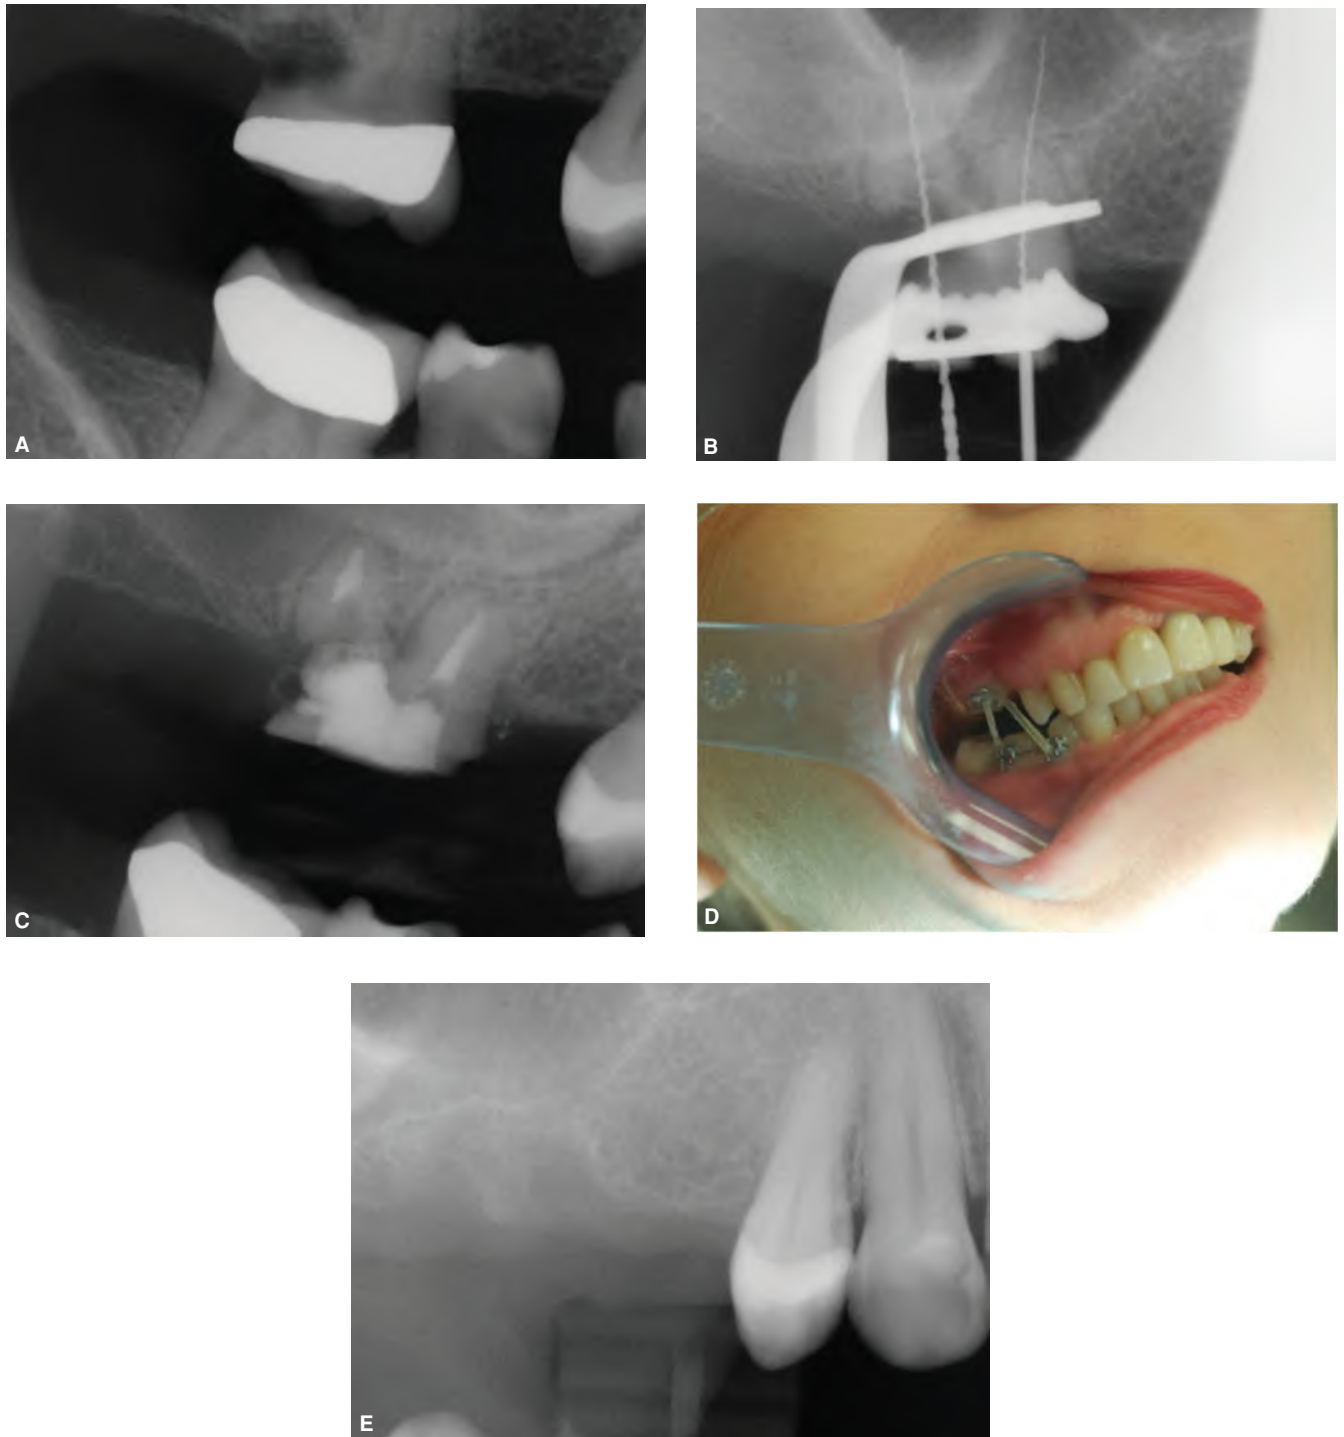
Orthodontic extrusion (extraction) of a symptomatic, non-restorable tooth in a patient with recent history of IV bisphosphonate use A. Pre-operative bitewing radiograph of tooth #3. B. Working length radiograph. C. Immediate postoperative radiograph. D. Three months after atraumatic extraction. The tooth has been atraumatically extracted. (Case courtesy of Dr. Robert Lee.)
